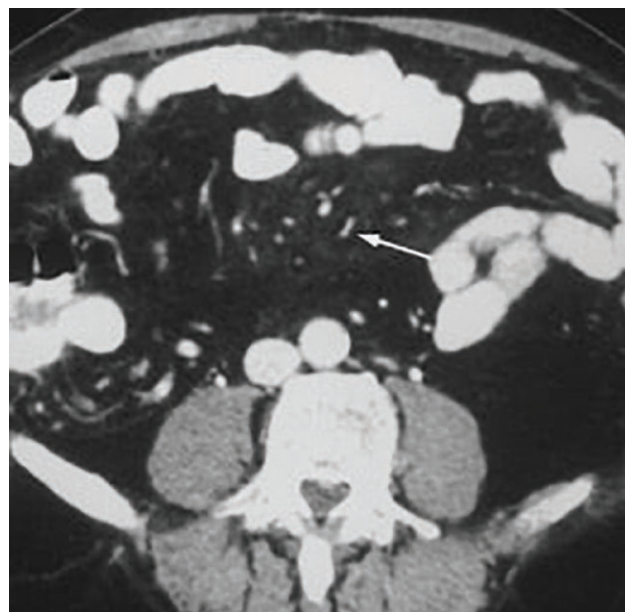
Fat ring sign (white arrow) seen on CT abdomen.
